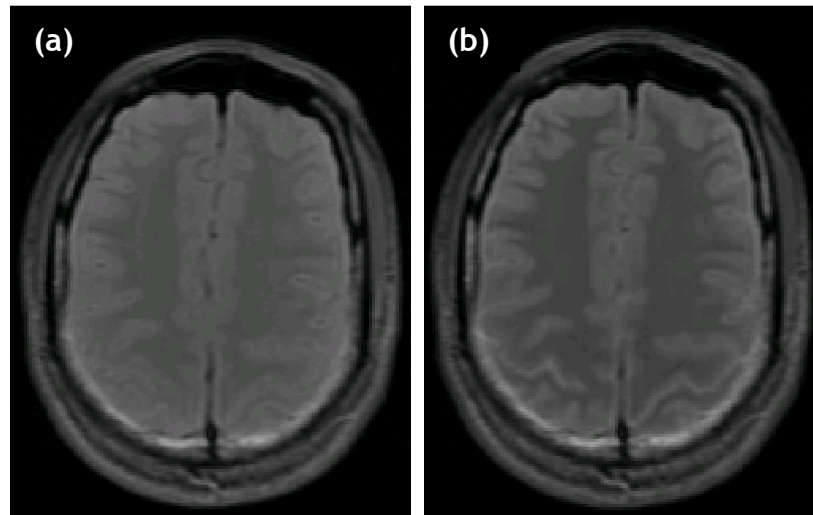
Axial MRI of the same subject acquired with the MT pulse switched OFF (a) and ON (b)
